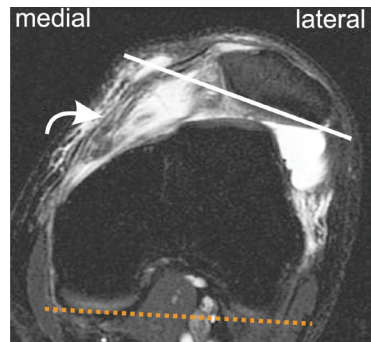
T2-weighted MRI with fat suppression in the axial plane, showing an inclined patella characterized by the angle formed by projection of the posterior bicondylar line (dashed line) and the lateral facet of the patella (straight line) with medial opening. Note that the patella is lateralized and the trochlea is also dysplastic, similar to the case in Fig. 3. There is also joint effusion and a lesion on the medial patellofemoral ligament (curved arrow).
